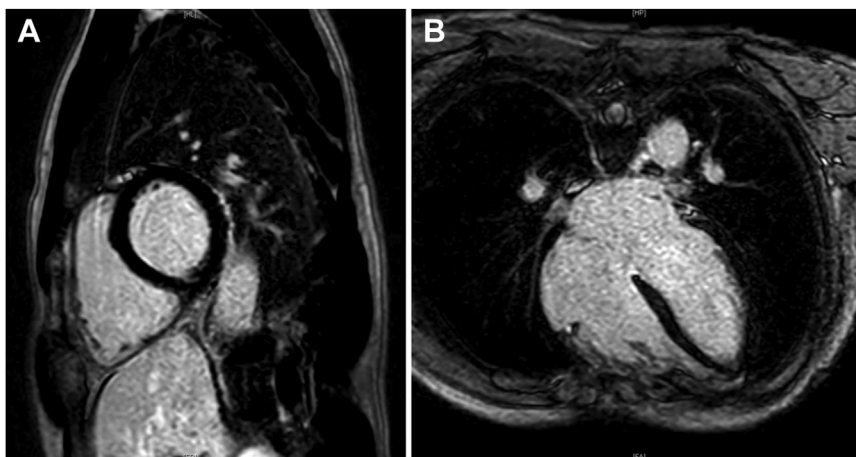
Cardiac magnetic resonance imaging. Sagittal (A) and transverse (B) images negative for late gadolinium enhancement or other abnormalities suggestive of myocarditis.
